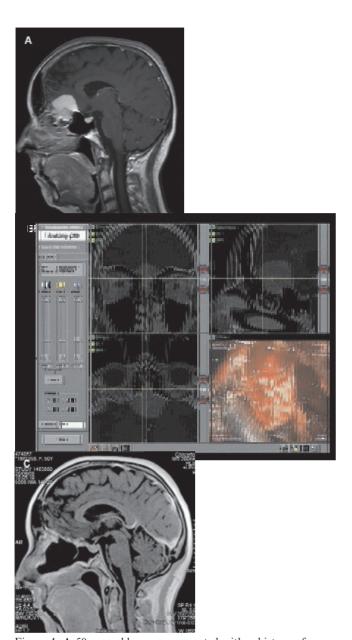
A 50-year-old woman presented with a history of spontaneous intermittent CSF rhinorrhea and anosmia. A) Sagittal gadolinium-enhanced T1-weighted MRI demonstrating an olfactory groove meningioma with infiltration of the cribriform plate and endonasal expansion into the middle and posterior ethmoidal cells. B) Intraoperative navigation image showing tumour removal via transcribriform approach. C) Sagittal gadolinium-enhanced T1-weighted MRI obtained 3 months postoperatively depicting no residual tumour.
